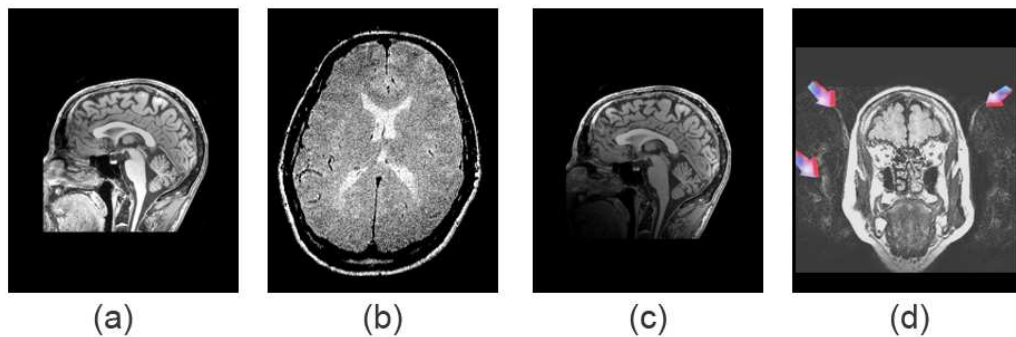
Examples of MR imaging noise. (a) Noise-free image, (b) inhomogeneity noise, (c) bias noise, (d) ghosting noise.*
